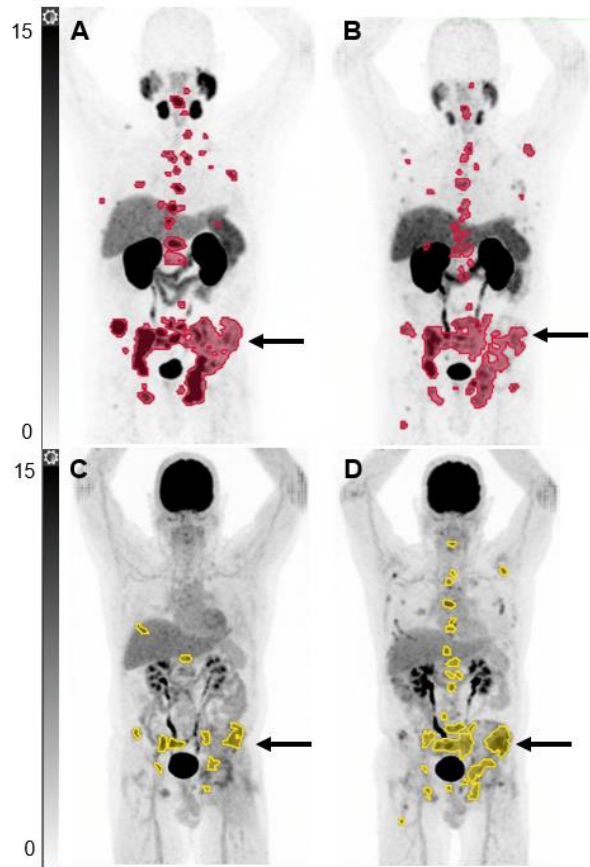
Quantitative analysis of baseline and post-treatment PSMA and FDG-PET from the same patient (A) baseline PSMA-PET (B) post-treatment PSMA-PET (C) baseline FDG-PET (D) post-treatment FDG-PET. Arrows indicate a lesion in iliac bone which reduced in volume and intensity on PSMA-PET, but increased in volume and intensity of FDG-PET.
